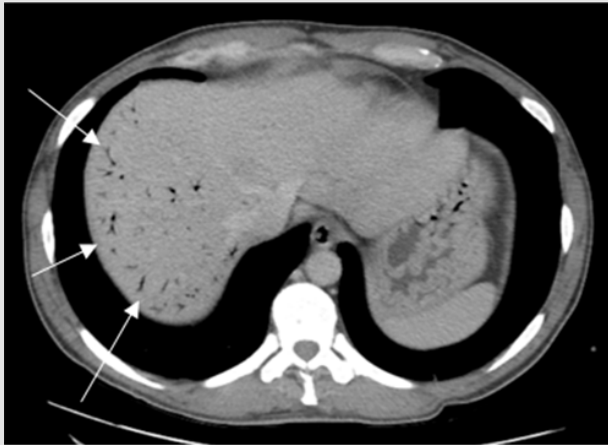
Contrast-enhanced CT (at 48h). Portal intrahepatic pneumatosis, with predominant peripheral location in the right hepatic lobe (marked by the arrows).
